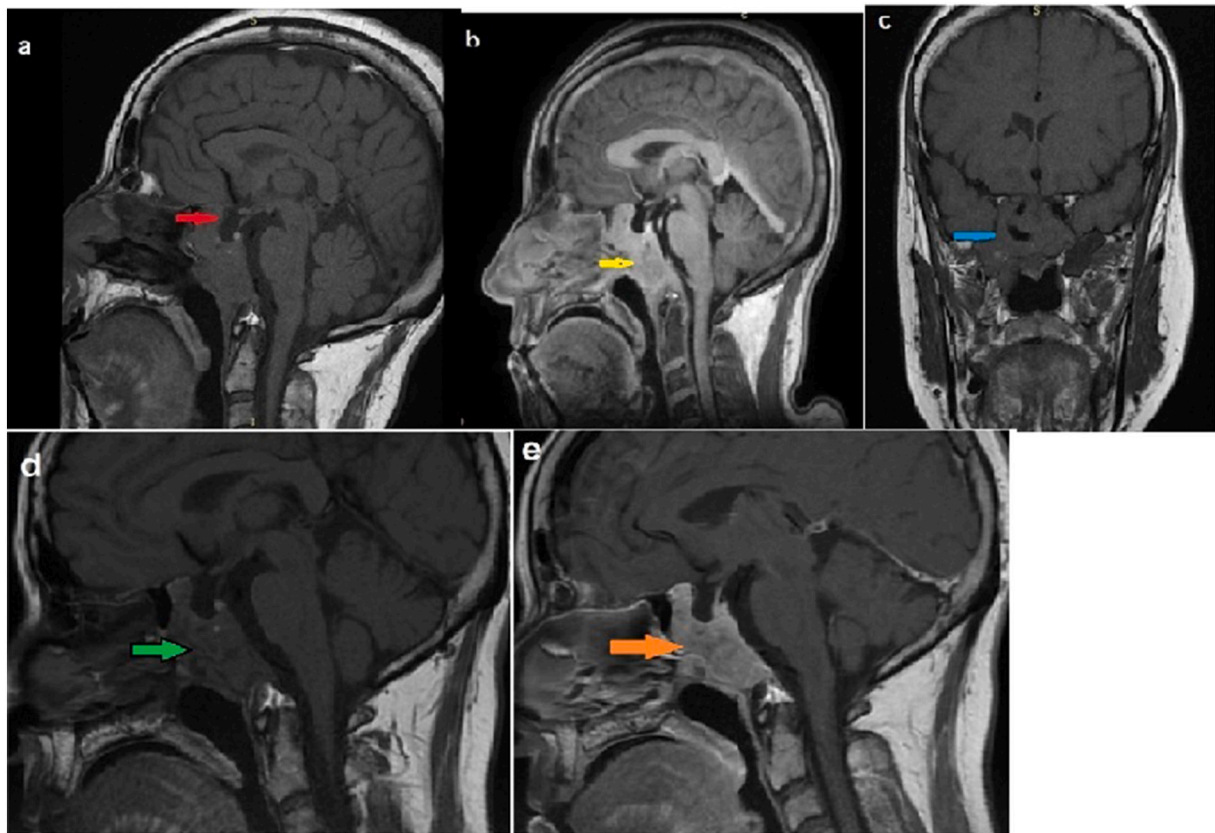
a: Sagittal MRI T1WI showing the mass within the clivus, isointense, and arachnoidocele (white arrow)
